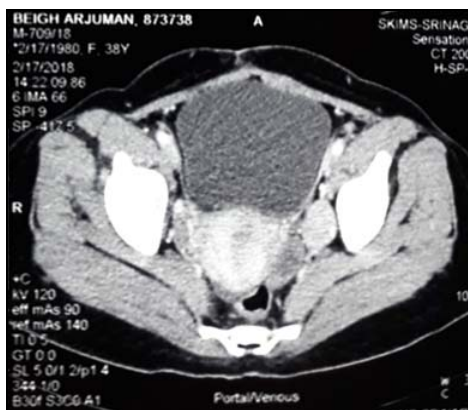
Computed tomography image of the patient showing the pelvic mass
